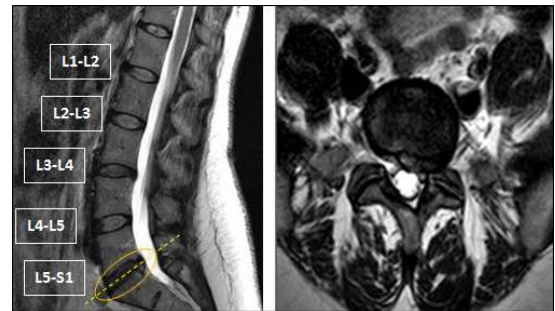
(Left) Sagittal view of a lumbar MRI showing an L5-S1 disc herniation and (Right) the corresponding axial view of the lumbar MRI confirming a left sided herniation.
